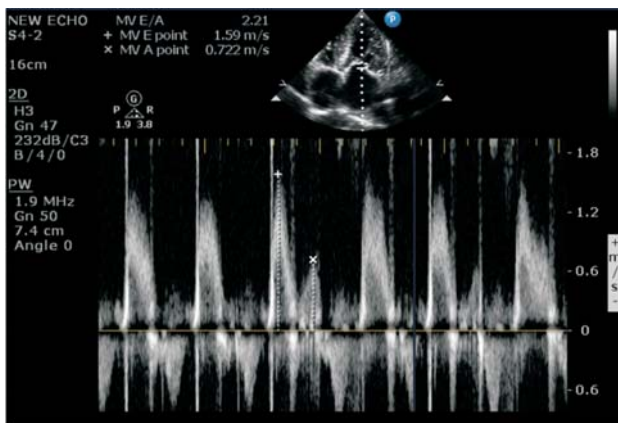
Mitral valve inflow velocity on pulsed wave doppler showing type 4 diastolic dysfunction.
